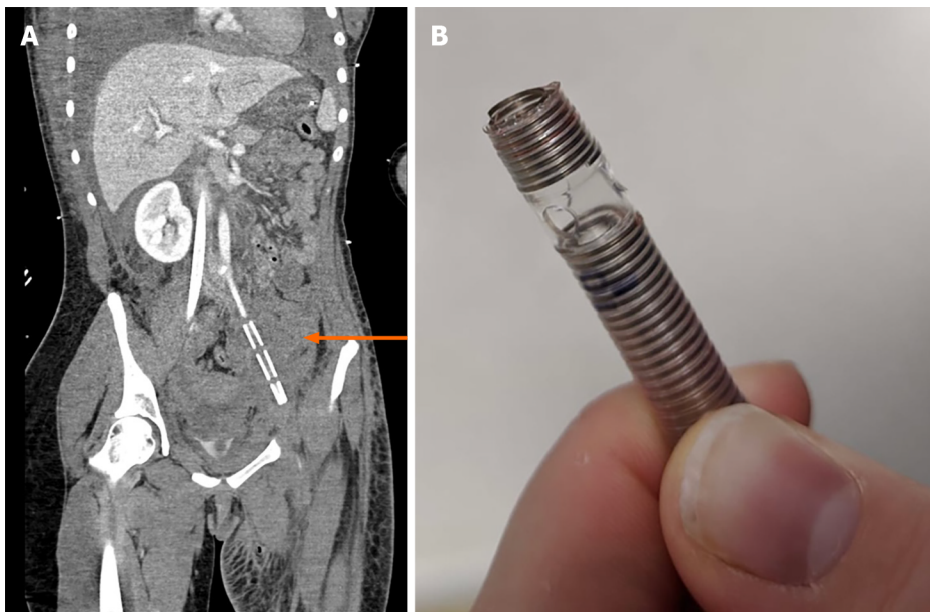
Computed tomography. A: Coronal computed tomography scan slice demonstrating retained extracorporeal membrane oxygenation (ECMO) cannula fragment (orange arrow); B: The torn end of the partially removed ECMO cannula.
